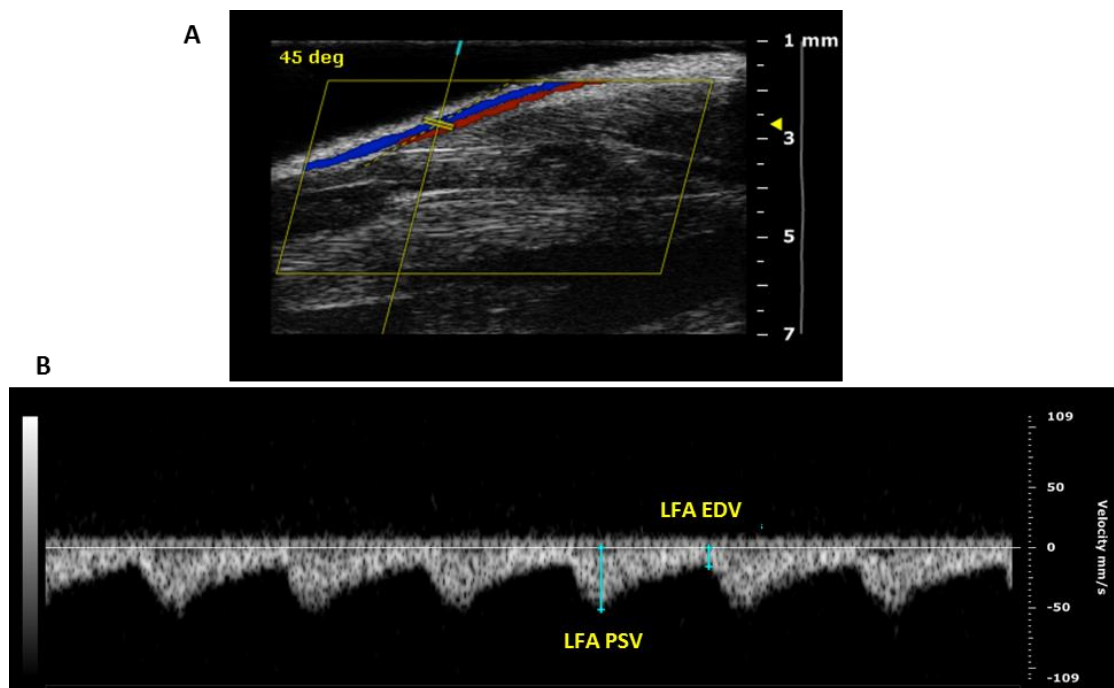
Measurement of resistivity index of the femoral arteries by ultrasound imaging
